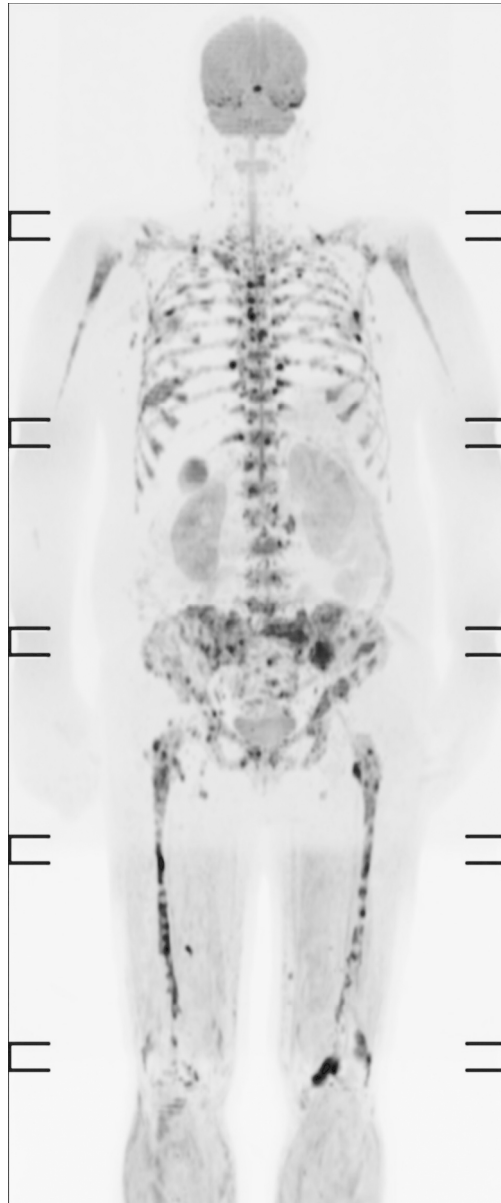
60 year-old male with multiple myeloma. Coronal reformatted whole-body DWI image with inverted greyscale contrast for $b=800$ s/mm² demonstrates diffuse tumor burden in low signal in the bone marrow.
